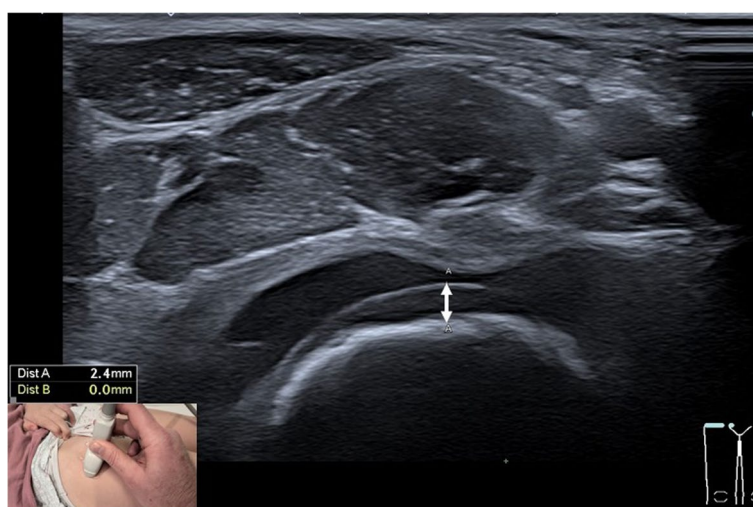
Ultrasound measurement of the femoral cartilage thickness performed in the transverse view. Example of the femoral head as seen in the transverse view. The double-headed arrow indicates femoral cartilage thickness
